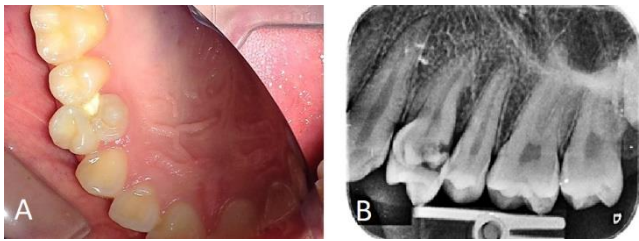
(A) Preoperative intra-oral photography. (B) Preoperative Periapical radiography
